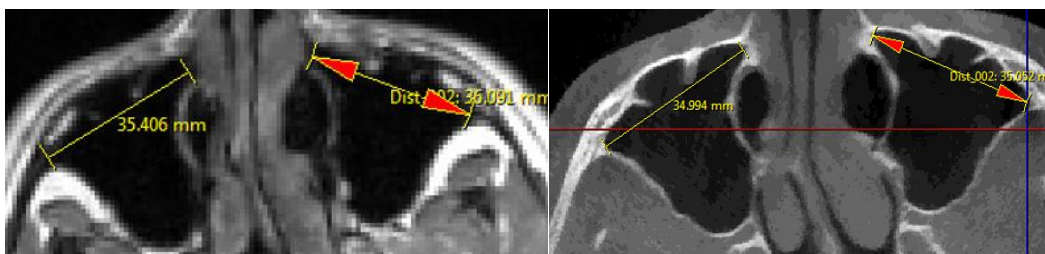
Measurement of the width of the maxillary sinuses. Shown here are right and left maxillary sinuses on CBCT slice (right) and MRI slice (left).
